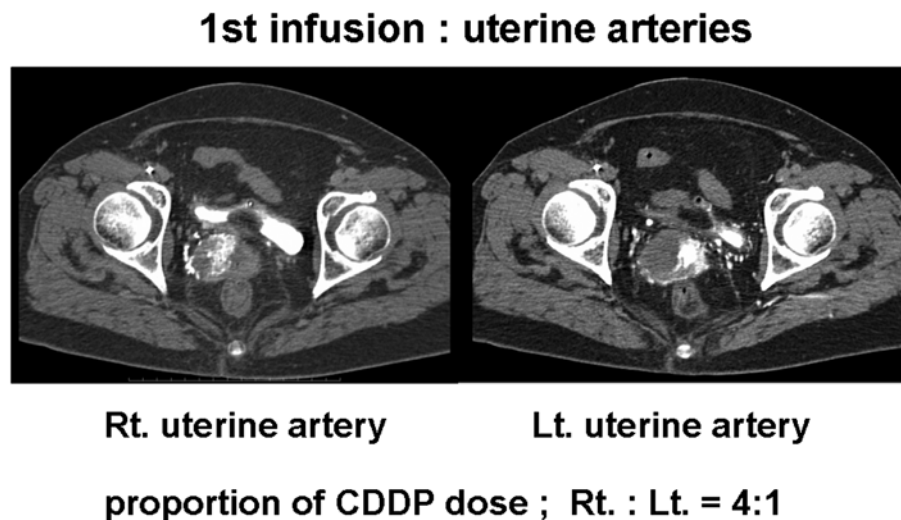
CT-angiography.
